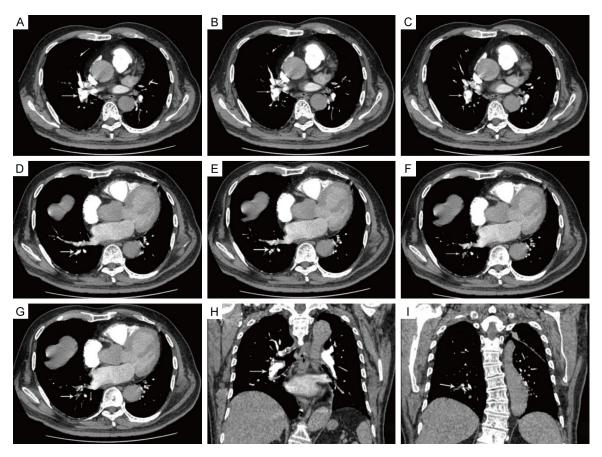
CT pulmonary angiography. Partial embolism of the main pulmonary artery in the lower lobe of the right lung (A-C and H); Pulmonary embolism in the secondary and tertiary branches of the lower lobe of the right lung (D-G and I).
